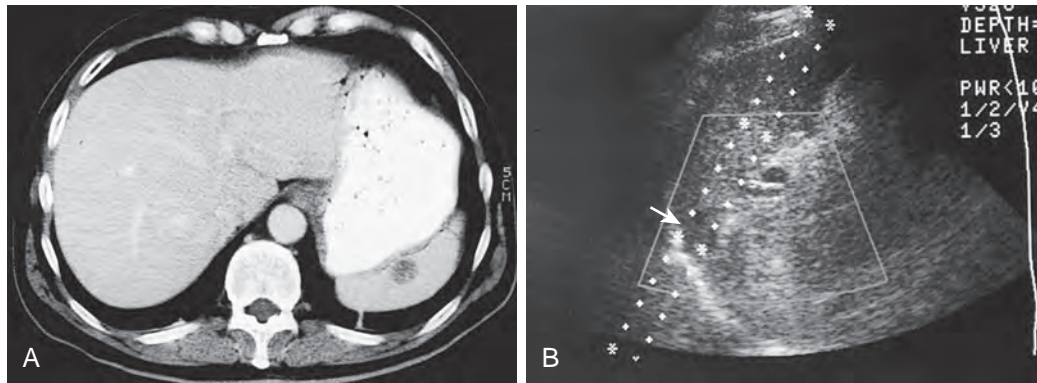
Images of a 52-year-old man with melanoma. A. Axial CT of the upper abdomen with contrast material reveals a 1.5-cm hypoattenuating mass in the spleen. B. Gray-scale ultrasound of the spleen in the longitudinal plane reveals a hypoechoic mass located deep in the splenic parenchyma (arrow). By an intercostal approach, the mass underwent biopsy percutaneously with the attached needle guide. Note that the mass is aligned within the parallel dotted lines, which represent the proposed path of the needle when it is advanced through the attached guide. Fine-needle aspiration revealed metastatic melanoma.
